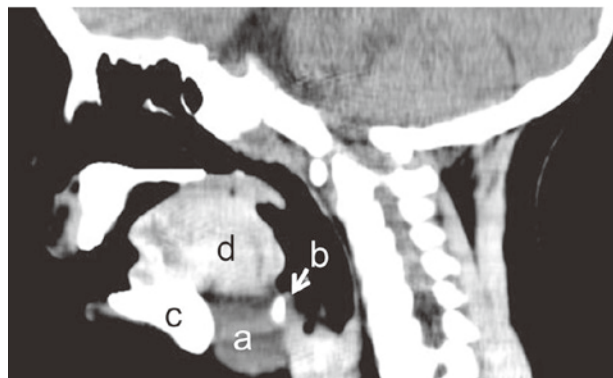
Sagittal computed tomography head scan demonstrates a cystic mass, measuring 3×4×3 cm, in the anterior midline of the neck. The mass is surrounded by the hyoid bone, mandible bone, and tongue. (a ; mass, b ; hyoid bone, c ; mandible bone, d ; tongue)
